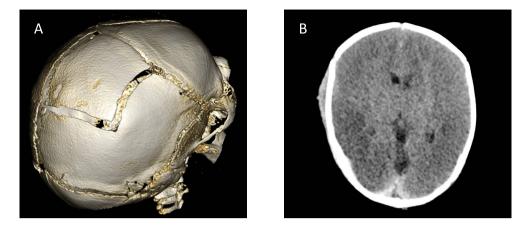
A three-dimensional shaded surface display (3D-SSD) of a skull fracture in a six-week-old boy with no history of trauma. The 3D-SSD images can be used to display the lesions to lay persons, e.g. parents or in court. These images should always be interpreted in combination with the original axial source data in order not to miss small lesions, which can be obscured in the rendering process, giving false negative results. Figure 4b. CT shows a relative high density of the basal ganglia, known as the reversal sign. This finding is a sign of diffuse, anoxic/ ischemic cerebral injury and carries a poor prognosis.
